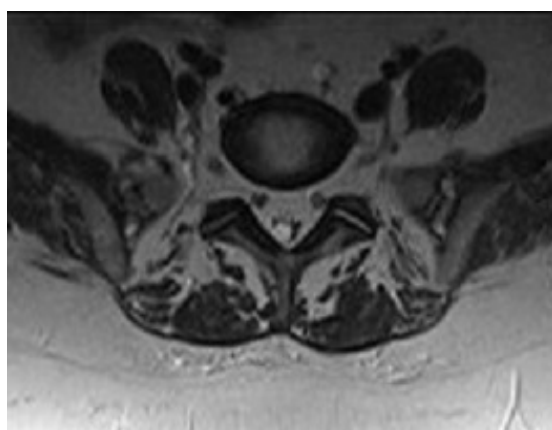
Axial T2-weighted MRI shows compression of the thecal sac and roots because of the lipomatosis.
